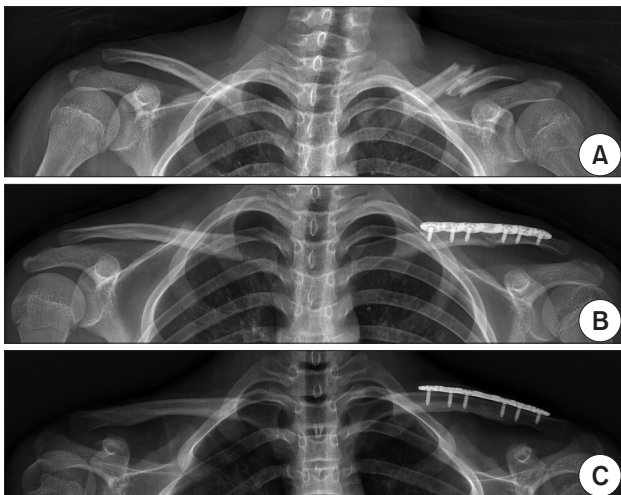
(A) Preoperative anteroposterior simple radiograph of a 14-year-old boy showing displacement and shortening of a midshaft fracture of the left clavicle. (B) Open reduction and internal fixation with a plate was performed. (C) The radiograph at postoperative 12 months showed complete union of the fracture site.
